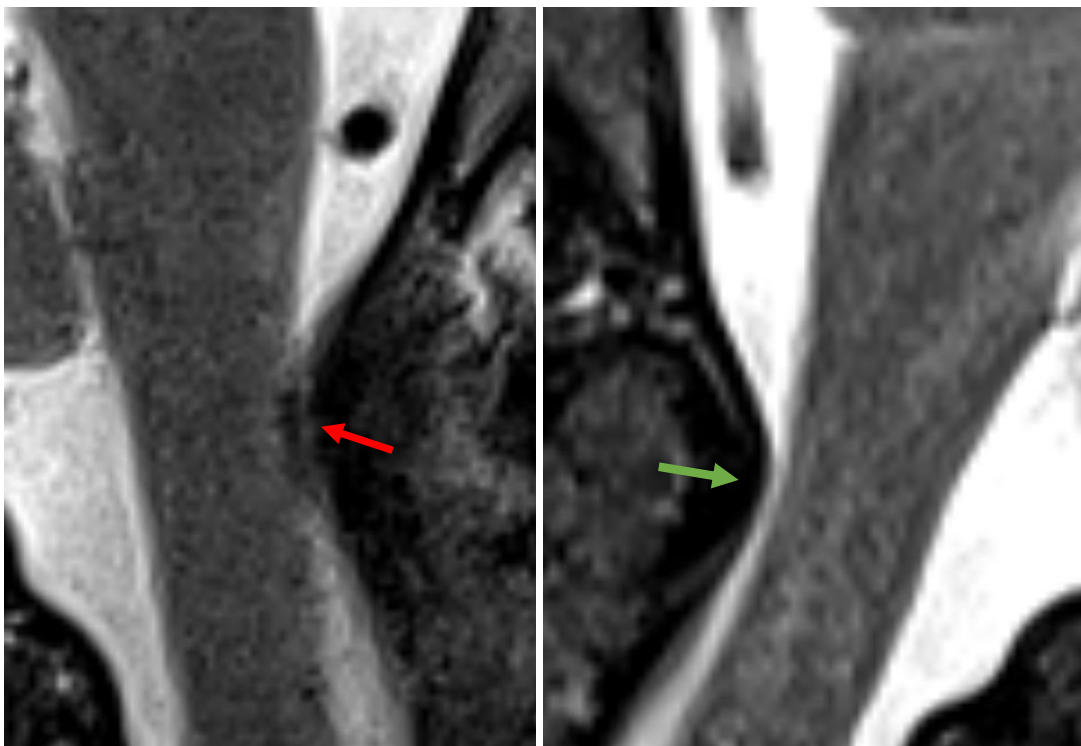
3T MRI, T2-weighted sagittal TSE.
